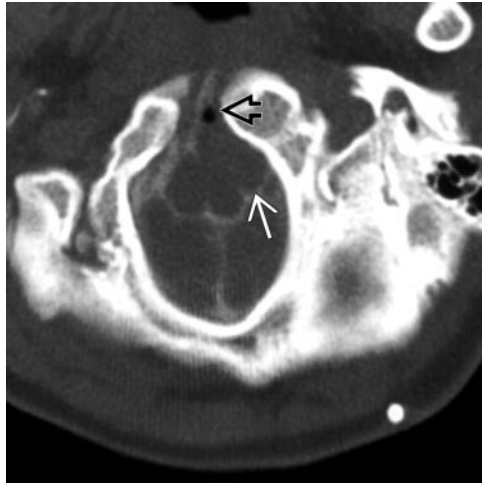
Patient 9. CT myelogram shows a well-delineated ovoid extra-axial mass (white arrow), at the foramen magnum level, associated with midline clefing of a craniocervical junction fusion anomaly (black open arrow). Bony anomalies are associated with approximately 50% of spinal NE cysts but have rarely been described in intracranial cases.
